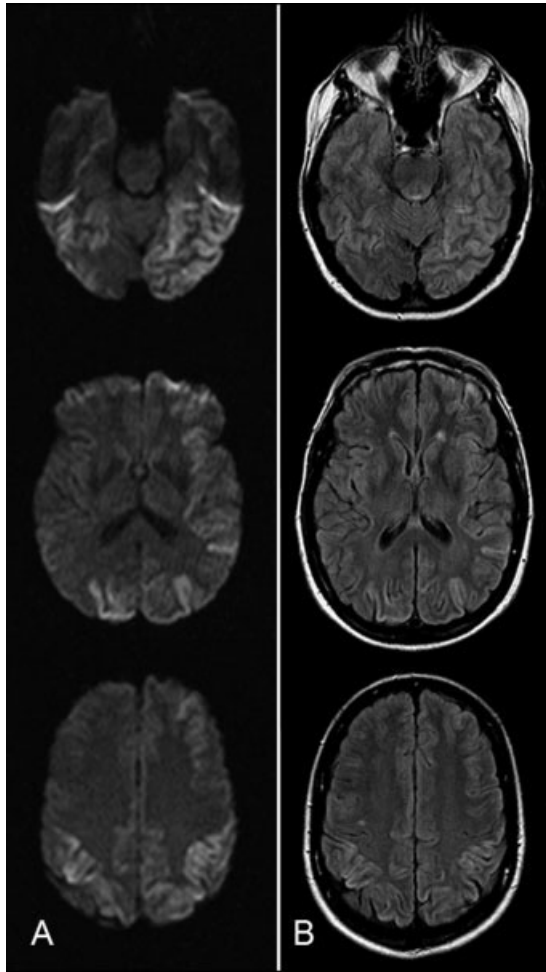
Representative diffusion-weighted (A) and FLAIR imaging (B) of the brain demonstrating diffuse restricted diffusion and corresponding FLAIR signal hyperintensity in a cortical ribbon pattern greater on the left than the right.
